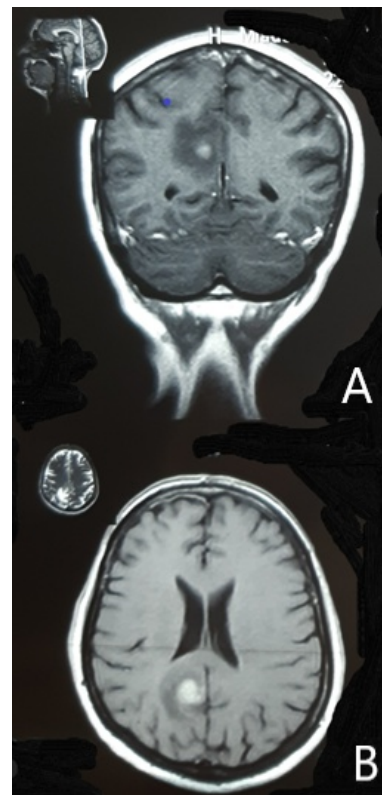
MRI of the endocranium, showing cerebral metastasis in the coronal (A) and axial (B) plane
